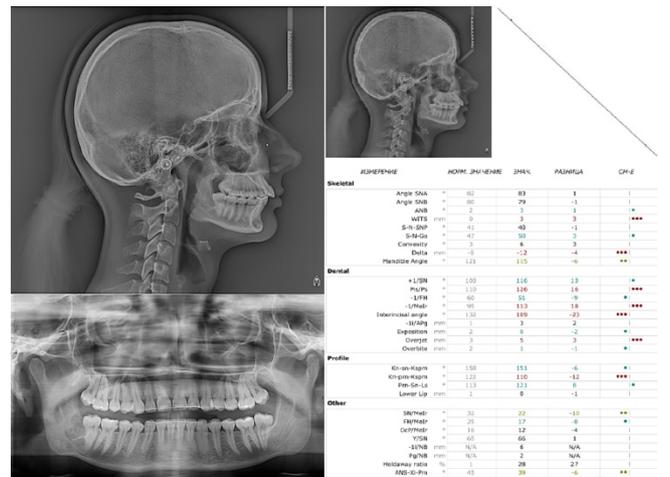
Orthopantomography, teleradiography, cephalometry.
